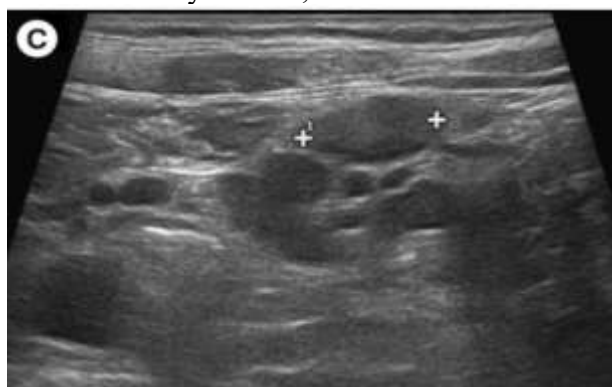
Ultrasonography in Crohn's disease. (Cicero & Mazziotti, 2021)
